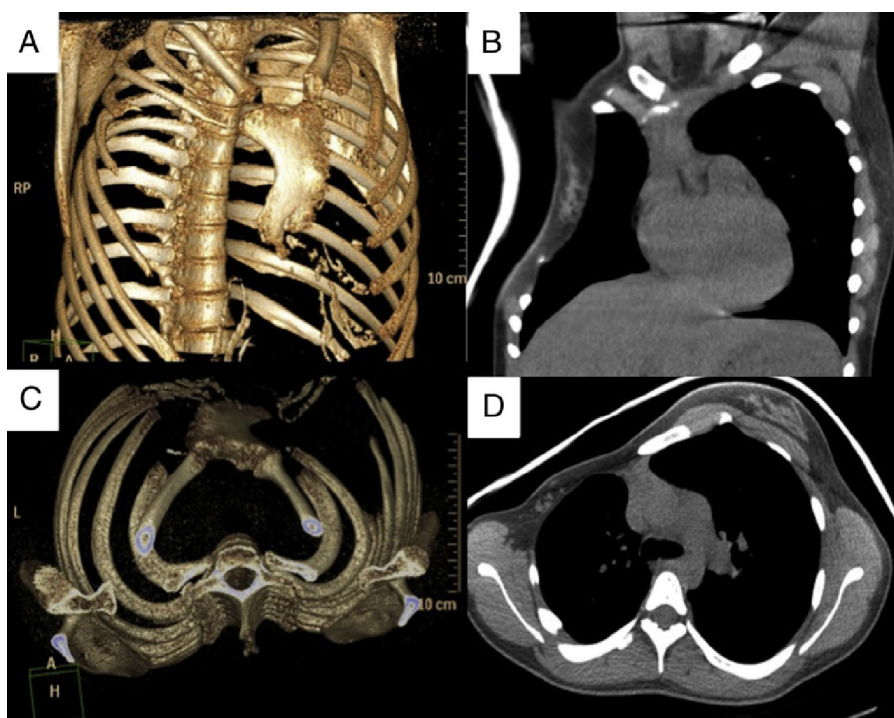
3D reconstruction of the chest wall defect: (A) anteroposterior view with rotation to the left; (B) craniocaudal view. View the defect on chest CT (mediastinal window): (C) coronal slice; (D) axial slice.
